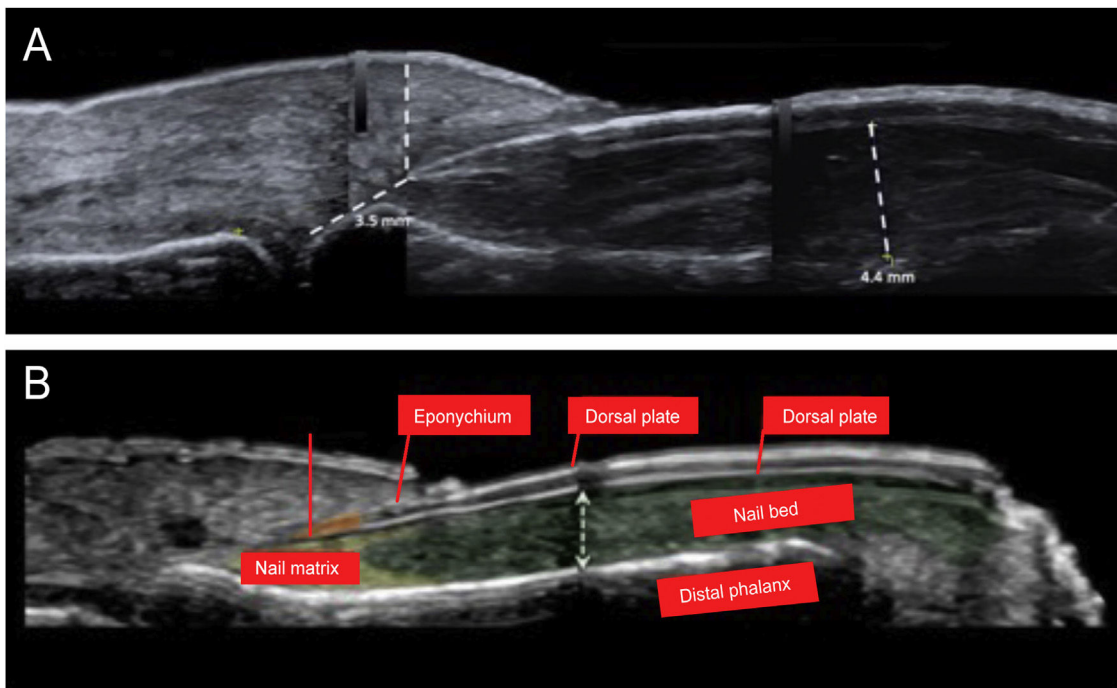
(a) High-resolution skin ultrasound with Doppler analysis performed with a 22 Mhz translator showed thickening of the nail bed with hypochoic appearance. It measured 4.4 mm and did not show any signs of hypervascularization on the Doppler exam. However, it did show a reduction in the space between the origin of the nail plate and the base of the distal phalanx: its measure was approximately 3.5 mm and presented a hypochoic inflammatory halo. (b) Normal anatomy of the nail.
